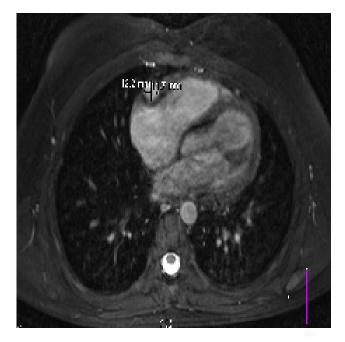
Magnetic resonance image of a 12.2 mm x 11.7 mm right coronary artery aneurysm in a young patient with Kawasaki's disease
